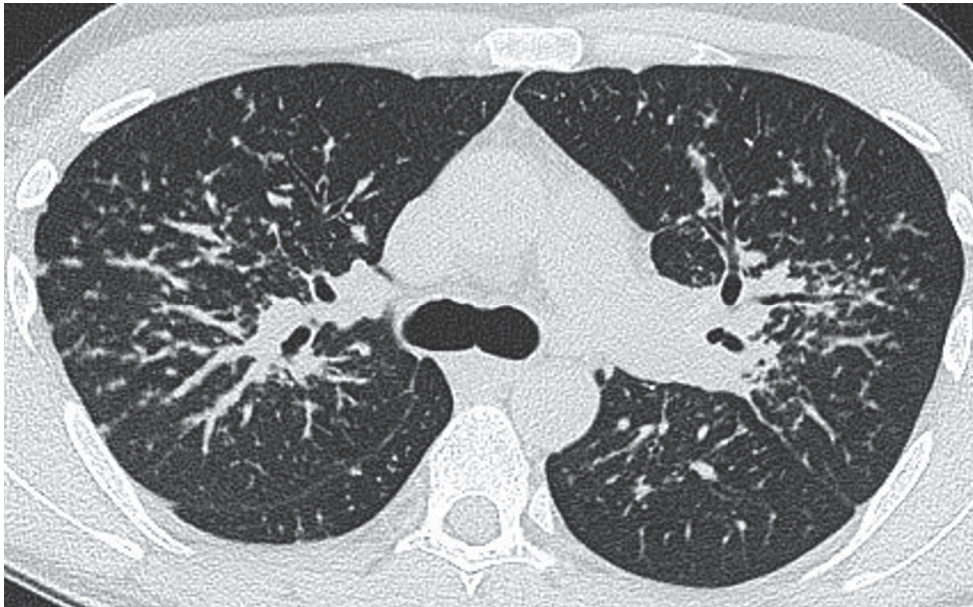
CT at the level of the carina in the same patient as in Figure 1. There is a roughly symmetrical bronchocentric micronodular infiltrate. More centrally, there is dense parenchymal opacification caused by conglomeration of nodules around the bronchovascular structures.
